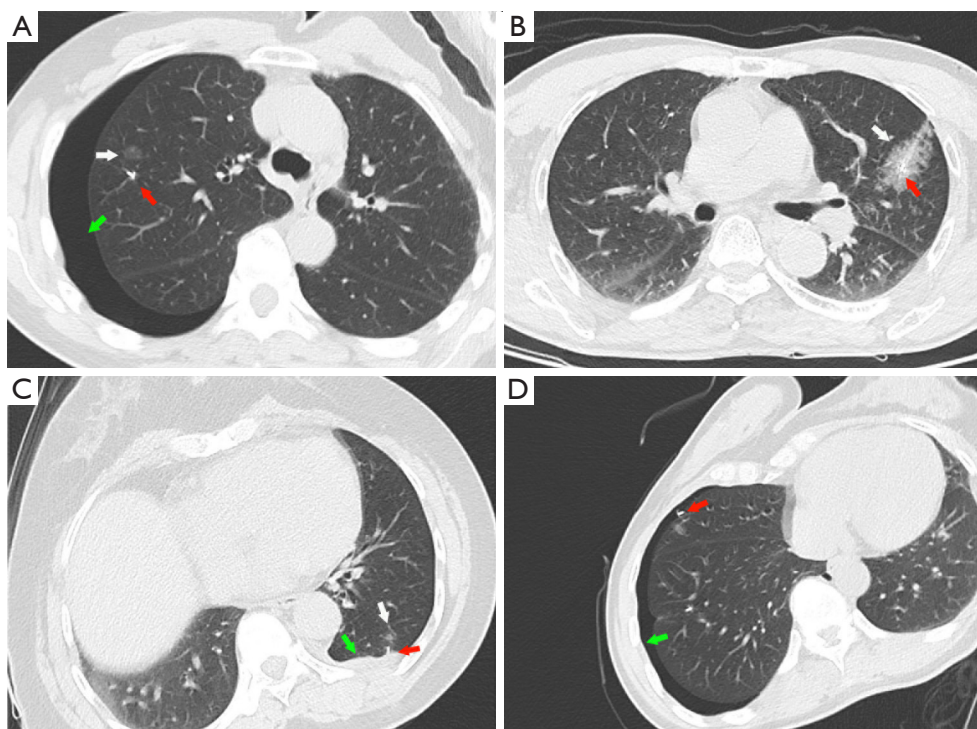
Complications and unsuccessful localization. (A) CT image showing asymptomatic pneumothorax (green arrow), with the claw (red arrow) and nodule (white arrow) in the right upper lobe. (B) CT image showing asymptomatic parenchymal hemorrhage (white arrow), with the claw (red arrow) in the left upper lobe. (C) CT image showing hemothorax (green arrow) with the claw (red arrow) and nodule (white arrow) in the left lower lobe. (D) CT image showing pneumothorax (green arrow) and displacement of the claw (red arrow) pushing against the lung tissue in right middle lobe. CT, computed tomography.
